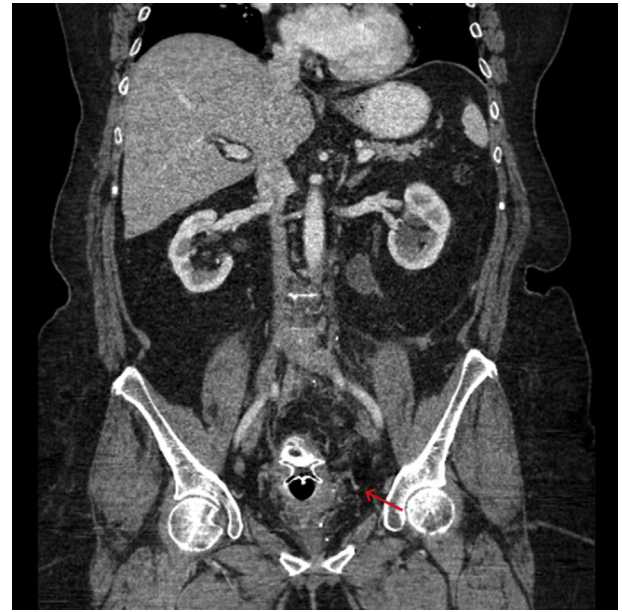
Follow-up CT image demonstrating the positioning of the cardiac septal defect occluder.
